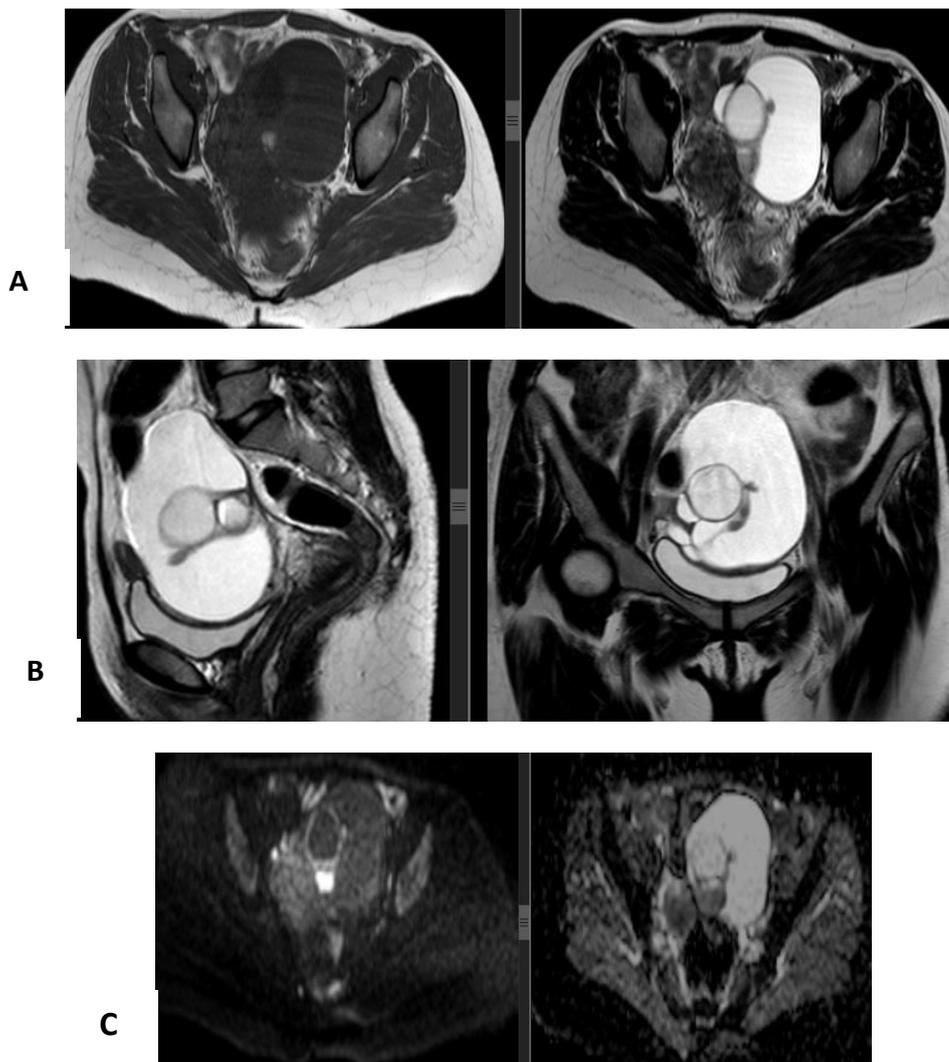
A 21 -years-old female patient, presented with lower abdominal pain, US showed left adnexal complex cystic mass; [A]: Axial T1-weighted image & T1WI with Fat saturation through the pelvis showing left adnexal isointense mass with focal peripheral hyperintensity that shows signal drop in the fat saturation sequence.[m: mass]; [B]: Axial, sagittal and coronal T2-weighted image through the pelvis showing complex partially solid partially cystic mass with small hypointense spot likely to be calcification [m: mass, u:uterus, r:rectum, ub:urinary bladder]; [C]: Axial diffusion-weighted imaging [DWI] and ADC mapping reveals that part of the mass has moderate high signal intensity on DWIs with mean apparent diffusion coefficient [ADC] = $0.9 \times 10^{-3} \text{mm}^2/\text{s}$; [D]: Post contrast Axial T1-weighted image with fat saturation through the mass reveals no significant post contrast enhancement; [E]: DCE-MRI, the solid part of the mass is not enhancing with bizarre shaped curve; [F]: Proton MRS showing sharp NAA, lactate/ lipids peaks and smaller lipid peak .Cho/Cr ratio: 0.3; Final diagnosis: Left ovarian mature cystic teratoma.
